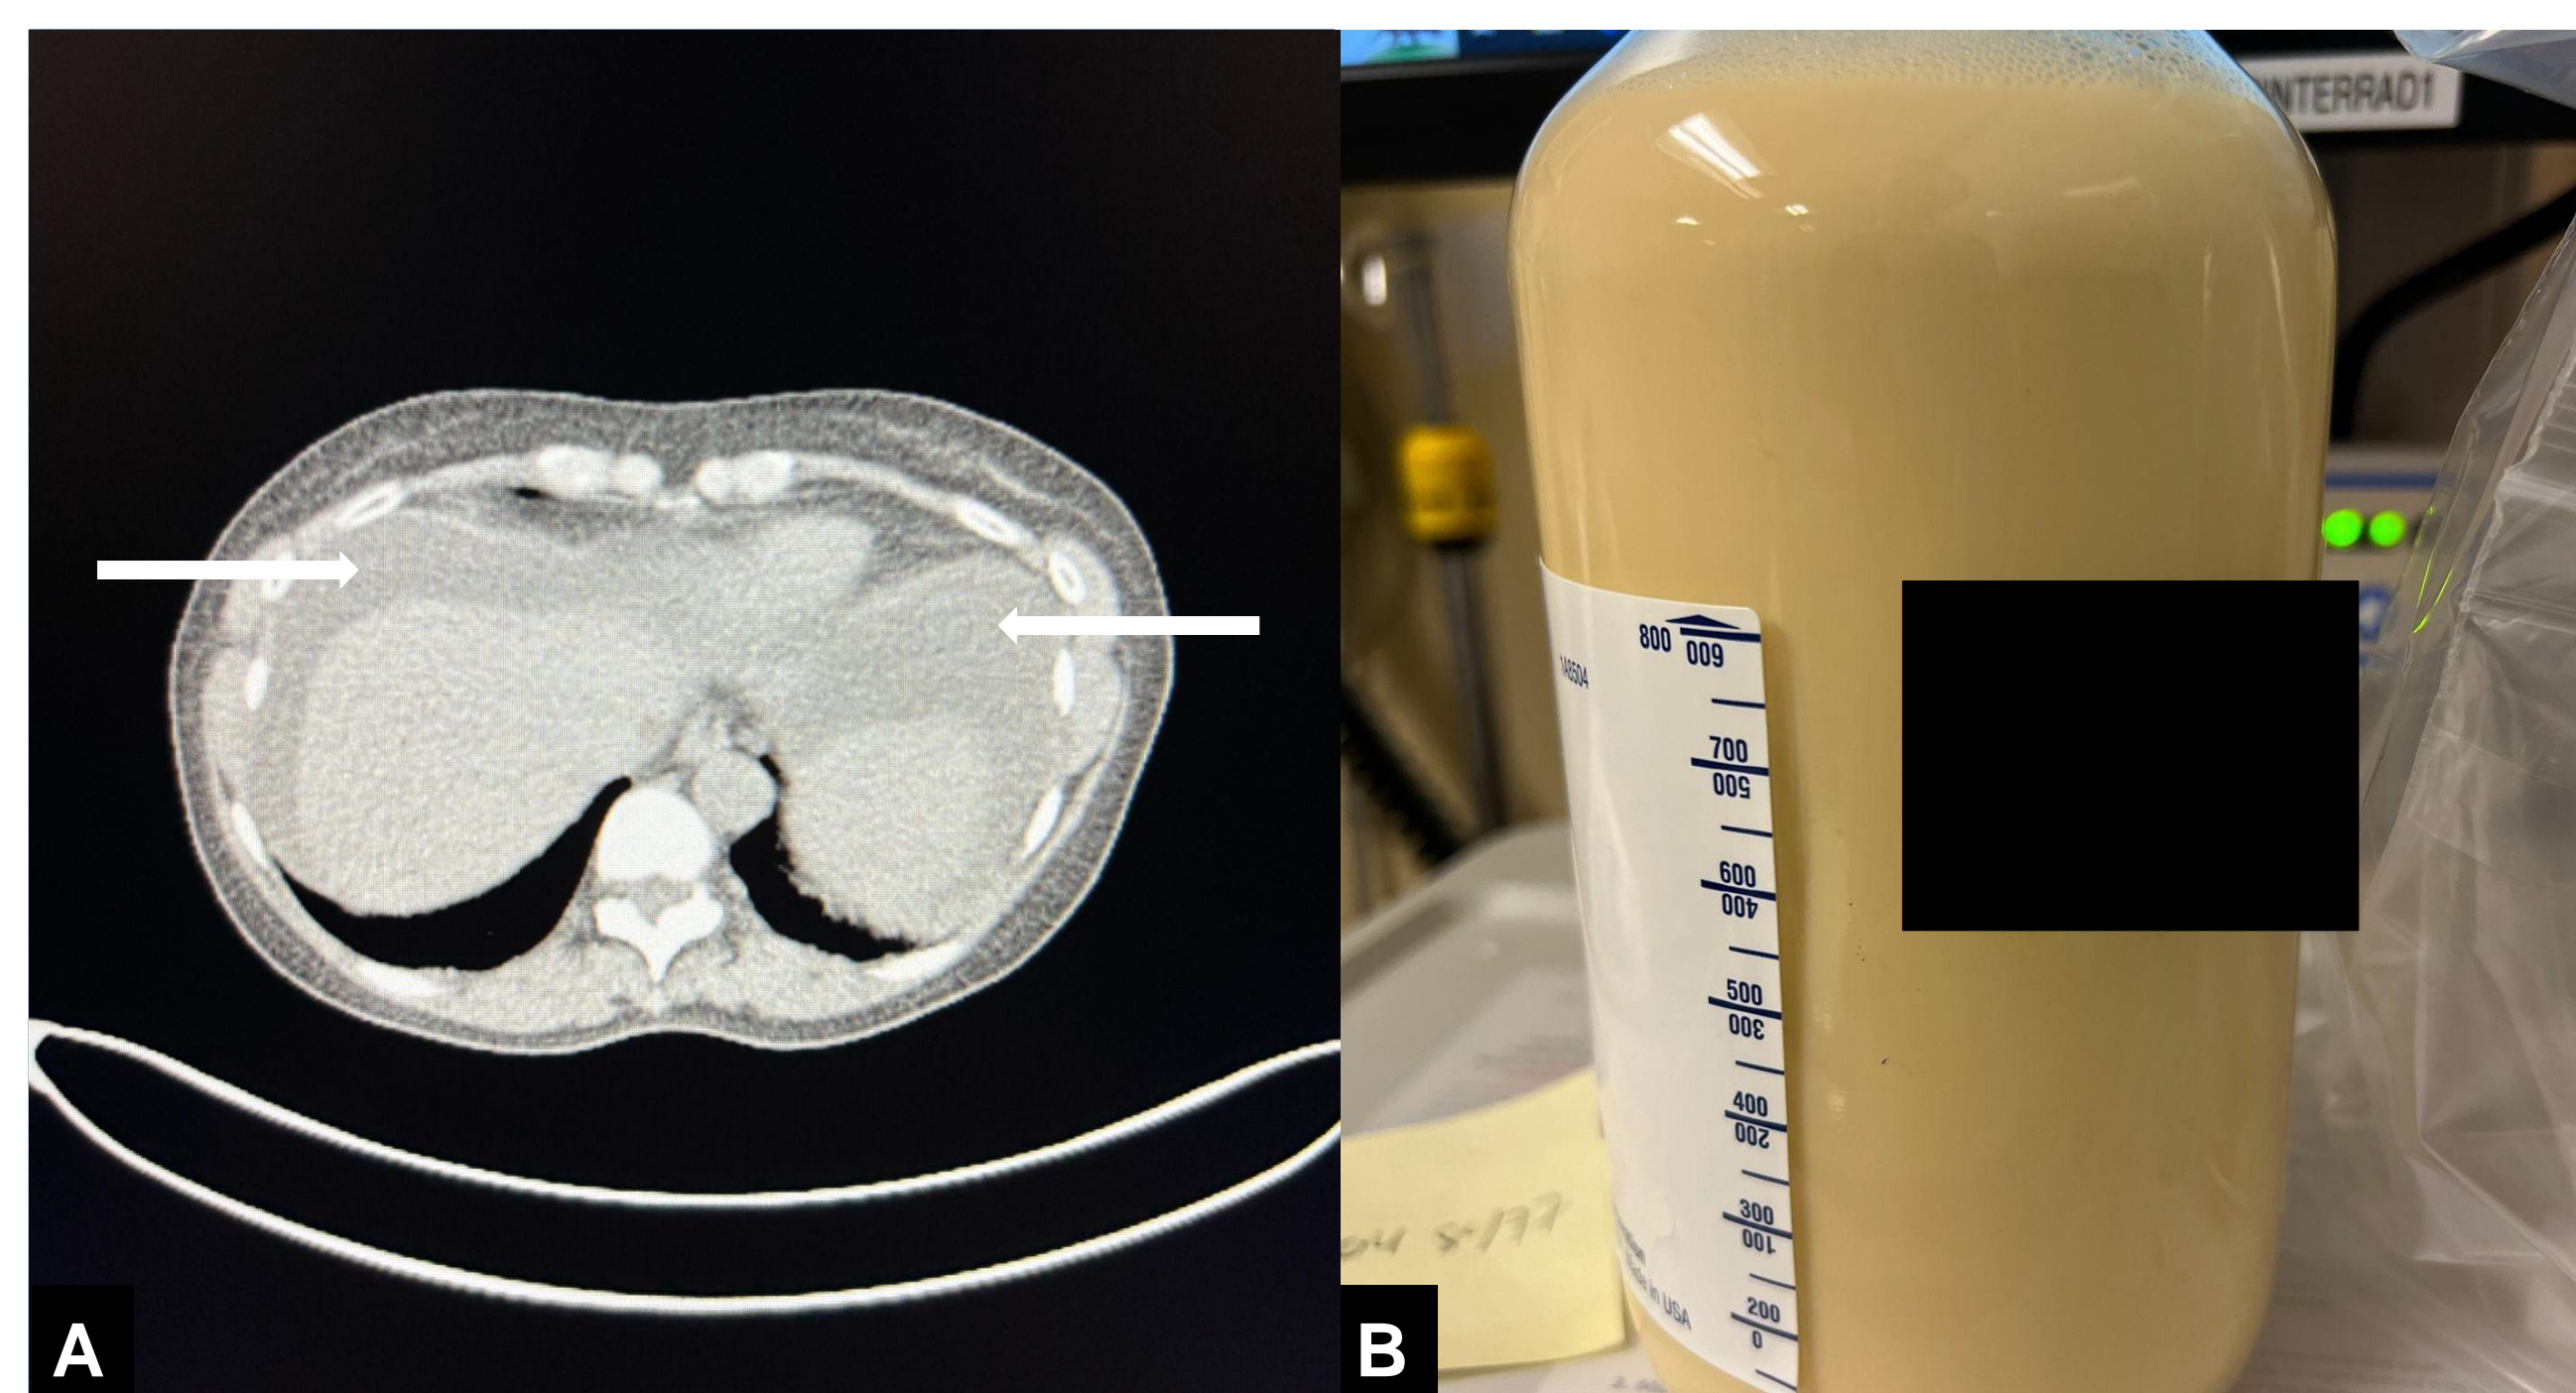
Chylous ascites. (A) CT imaging showed the presence of ascites (arrows). (B) Paracentesis removed 3.1 L of the opaque, 'milky' ascites that labs confirmed to be chylous.
